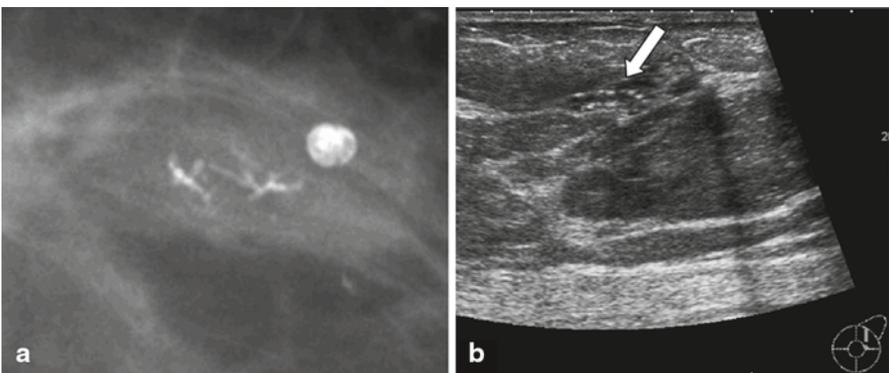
Mammographic screening. a Microfocus magnification view of the upper-outer quadrant of the left breast reveals a small cluster of typical casting-type calcifications. b Targeted ultrasonography shows the calcifications as small punctate white spots (*arrow*). Ultrasound-guided needle biopsy confirmed DCIS of grade 3
